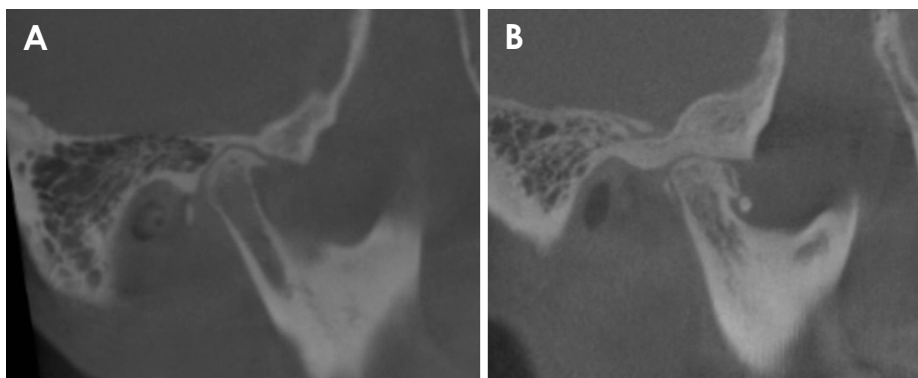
Sample cone-beam computed tomography images depict joint space narrowing and joint loose bodies, selected from subjects in this study. A. Joint space narrowing. B. Joint loose bodies.
